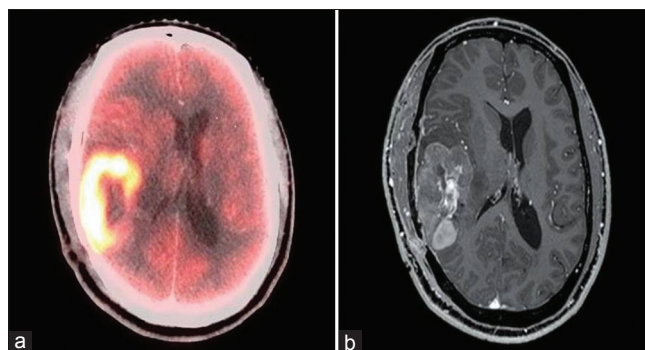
(a) Pet – CT scan and (b) T1-MRI showing right parietotemporal lesion with solid and cystic components with significant perilesional edema and midline shift
